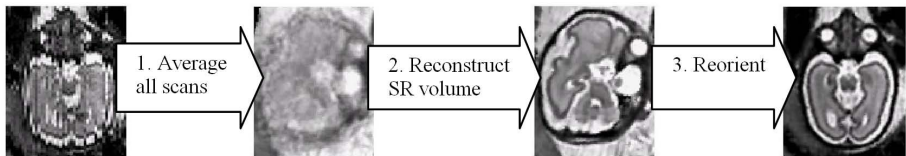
The preprocessing steps in fetal brain MRI analysis: 1) an initial estimate of fetal brain volume is obtained by averaging original SSFSE scans, 2) a volumetric fetal brain MRI is reconstructed via iterations of inter-slice motion correction and volume reconstruction [2], and 3) the reconstructed image, which is arbitrarily oriented in the reference coordinate system, is reoriented to an orthogonal plane of the fetal brain by applying the inverse of the direction cosines matrix of the original scan [8].
